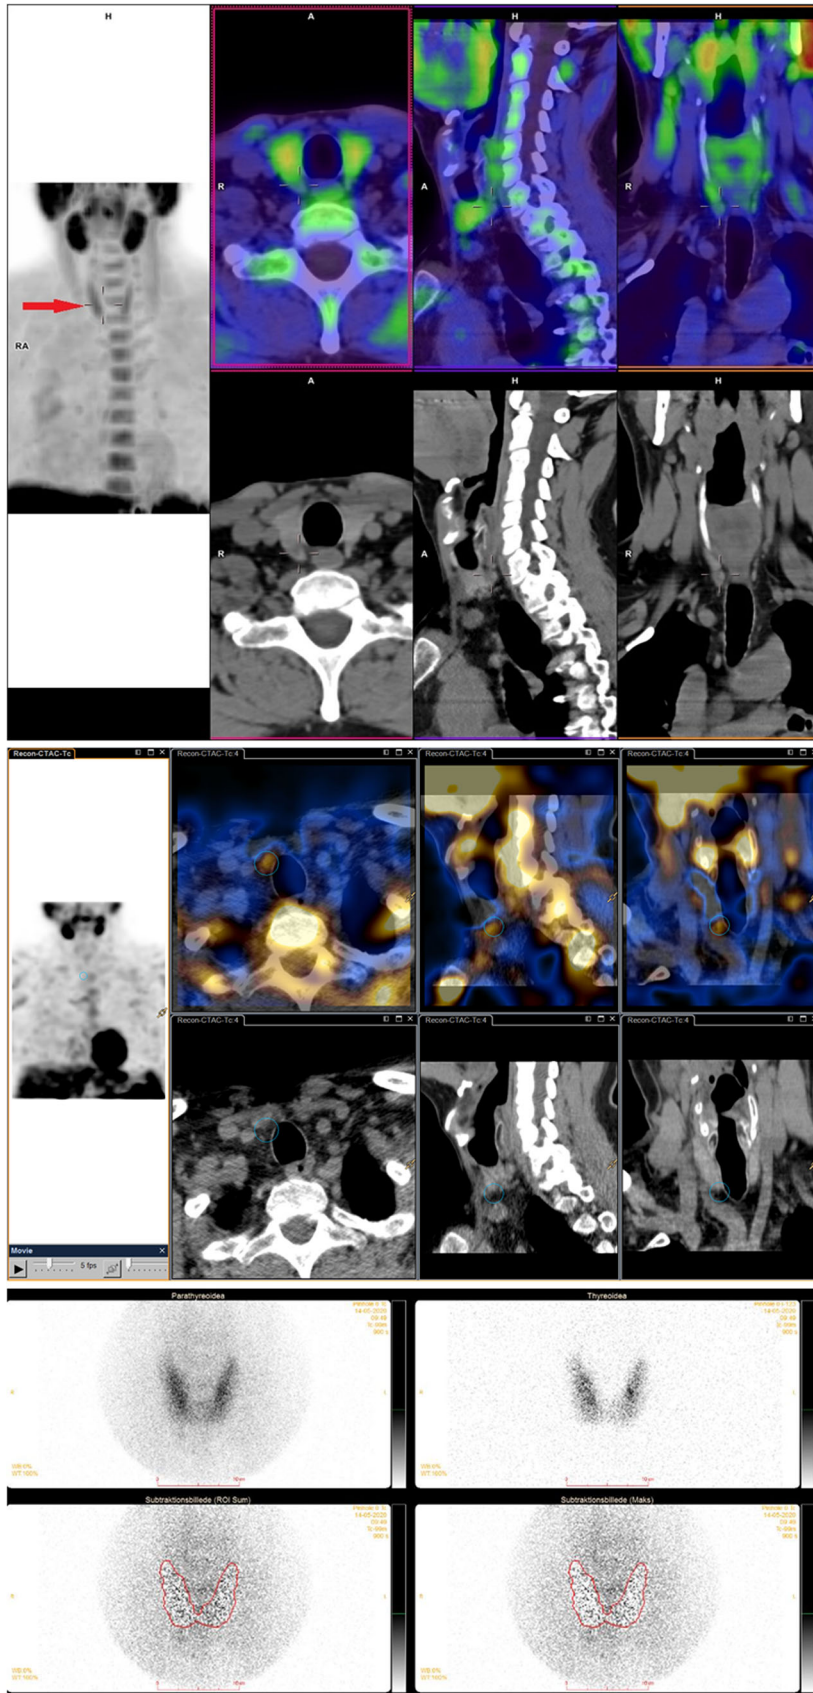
Images of a patient diagnosed with primary hyperparathyroidism. Parathyroid hyperplasia. Top ^{11}C -Choline PET/CT. Middle: Dual-isotope subtraction parathyroid scintigraphy with $^{99\text{m}}\text{Tc}$ -MIBI and ^{123}I iodide SPECT/CT. Bottom: Dual-isotope subtraction planar pinhole image. Arrows mark the suspected hyperfunctioning parathyroid gland in the lower right quadrant of the thyroid gland. The suspected HPG was surgically removed and pathology showed parathyroid hyperplasia
